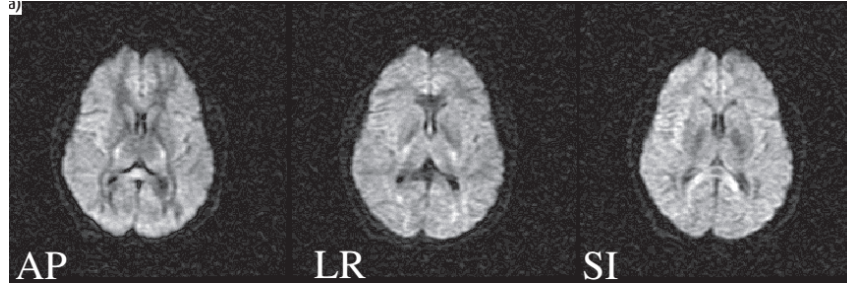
Example of a DWI image set. Each image encodes a different diffusion direction: AP denotes anterior-posterior; LR, left-right and SI, superior-inferior [26].
